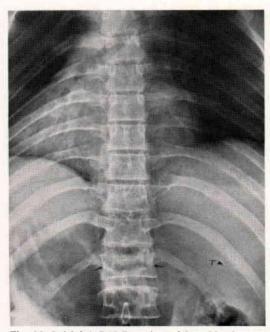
Initial A-P X-Ray view of Case No. 1.
